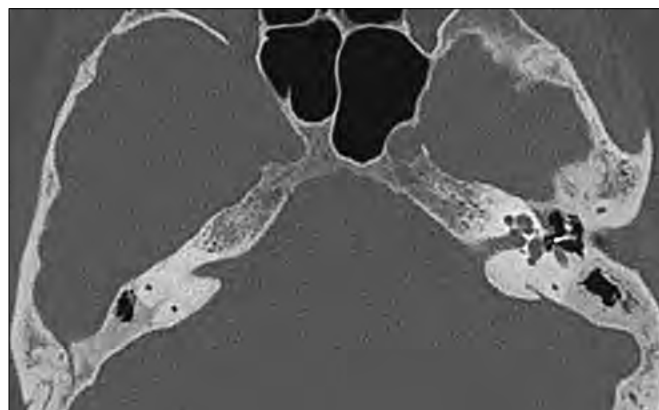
Temporal bone high resolution computed tomography, axial view. On the left, the end of the prosthesis appears dislocated from the oval window.
